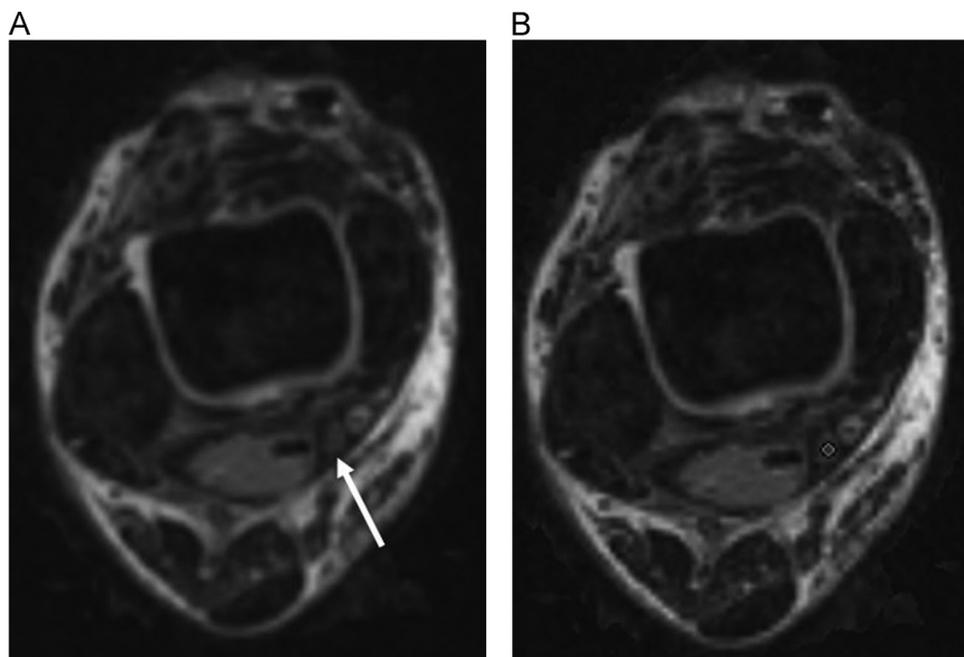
Fused axial DTI and PSIF MR images of the ankle obtained for posterior tibial nerve FA and ADC measurements. In (A), note the normal appearing posterior tibial nerve in short axis (arrow). (B) An ROI (circle) was placed within the posterior tibial nerve boundaries to measure FA and ADC values.
